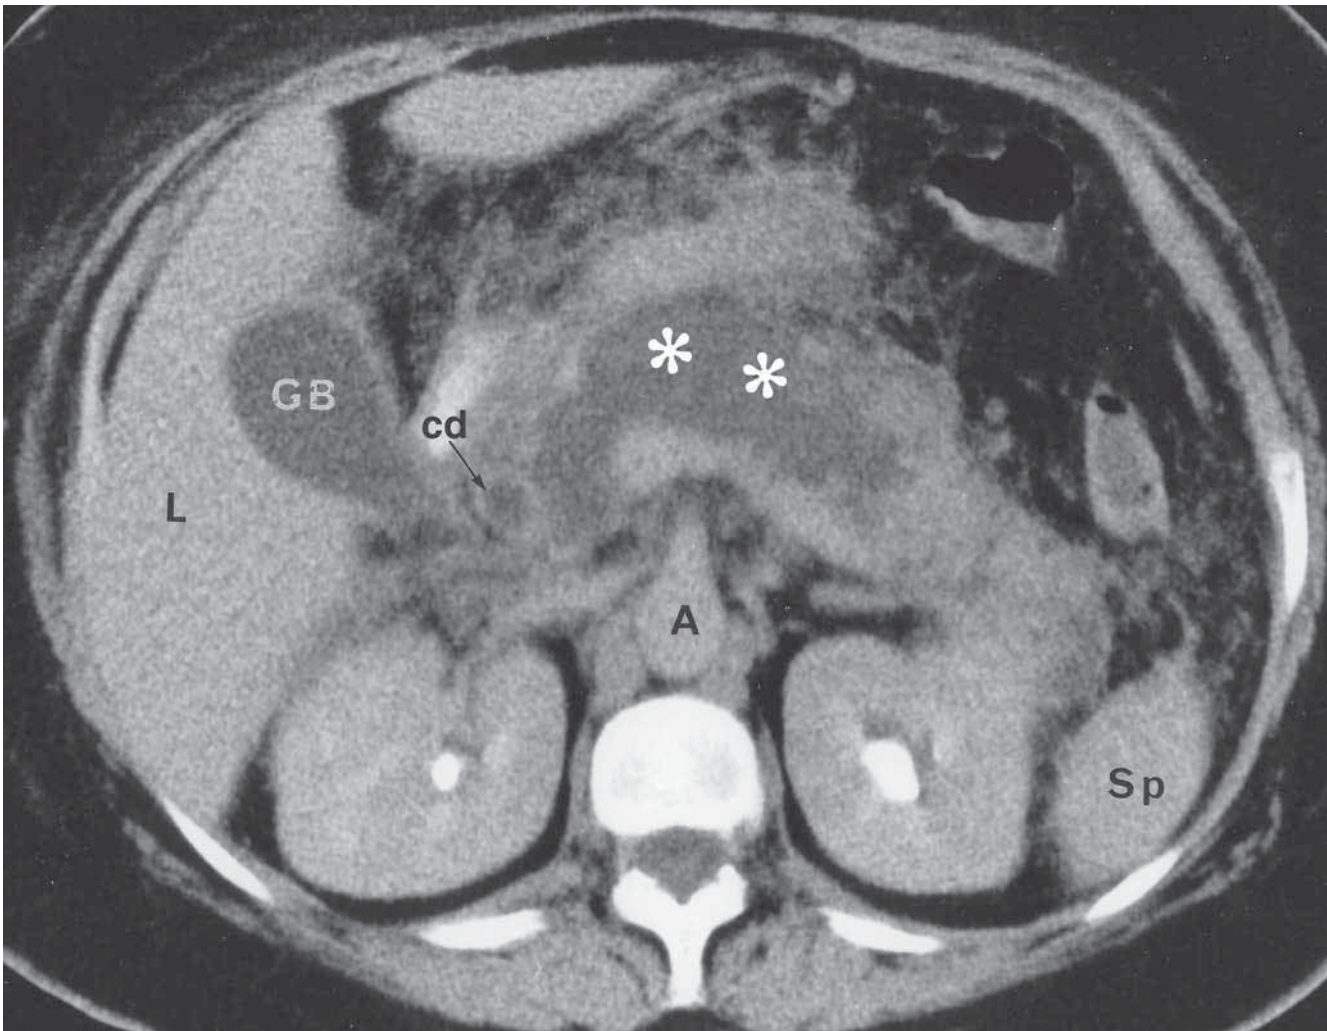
CT Showing Diffuse Inflammation of the Pancreas
